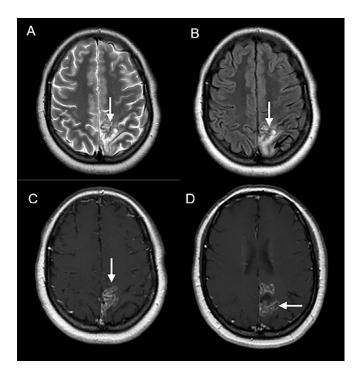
MRI findings after 2-month intensive phase treatment period. (A) T2WI shows an important reduction in the dimensions of the lesion (white arrow), with the appearance of areas of high signal intensity within the lesion. (B) FLAIR demonstrates a significant reduction in the hyperintense areas (black arrow) suggestive of vasogenic edema in white matter and surrounding the lesion (white arrow). There is no more midline shift. (C and D) T1WI with contrast injection confirms the reduction in size of the lesion (white arrows).
